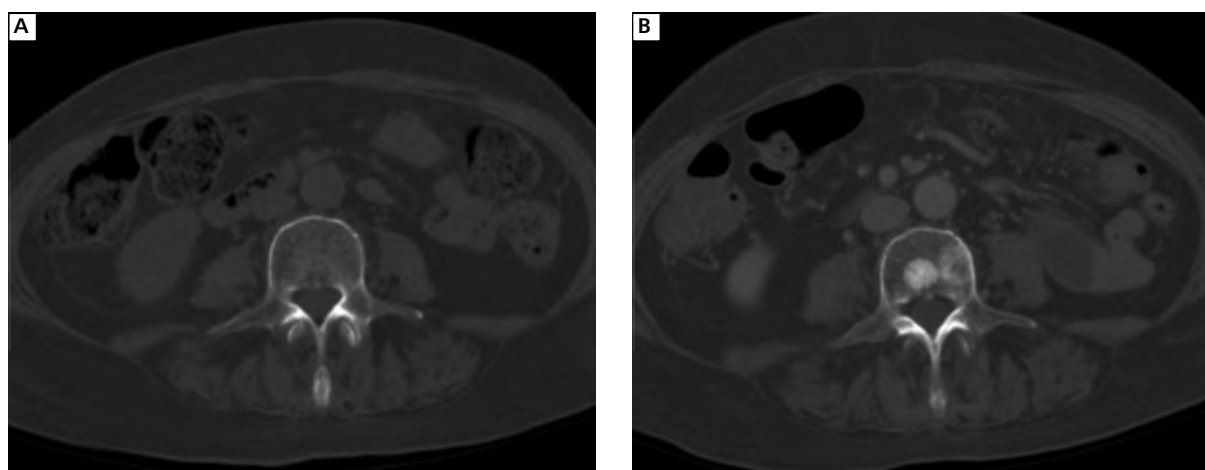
Osteoblastic reaction. CT analysis in a patient with non-small cell lung cancer during chemotherapy. (A) image before initiation of treatment — no lesions in bones visible; (B) image after a successive cycle of chemotherapy — appearance of blastic foci in the vertebral body corresponds to calcification of metastases which were present but not visible in the initial TK examination
